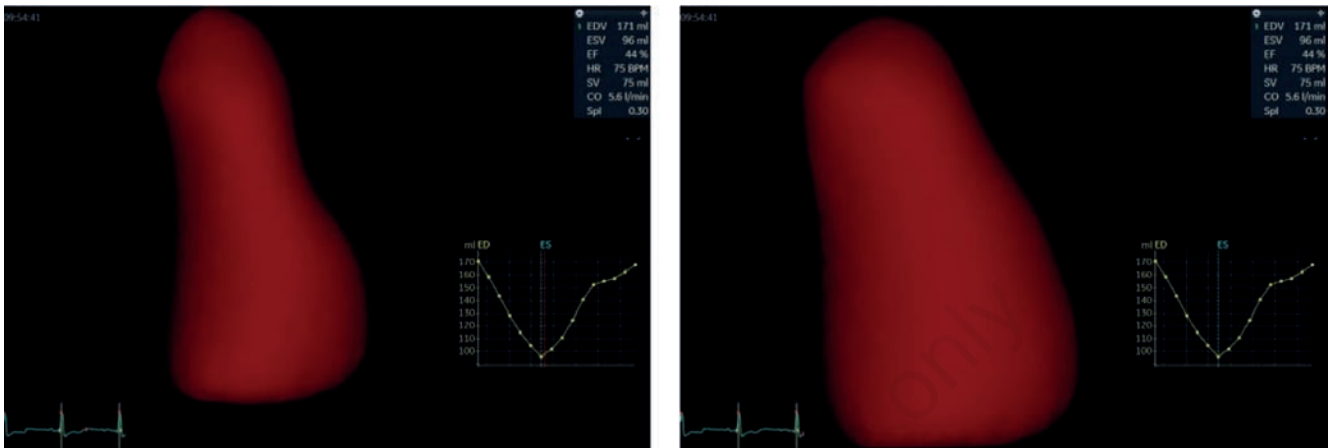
3D-echocardiography: akinesia of apical segment of left ventricular lateral wall. Systole (left) and diastole (right).
